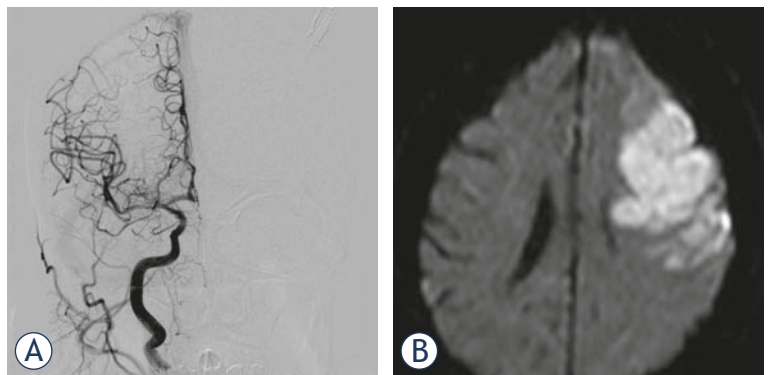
(A) Digital subtraction angiography (DSA) after mechanical recanalization. Right M1 mechanical recanalization (aspiration device) led to complete flow restoration. (B) MR diffusion weighted imaging (DWI) scan taken 6 days after mechanical recanalization: complete salvage of the affected right middle cerebral artery (MCA) brain parenchyma (recanalization at 7 hours after stroke onset). In contrast, subsequent persistent left M2 occlusion without collateral flow resulted in significant stroke within 3 hours after stroke onset.
